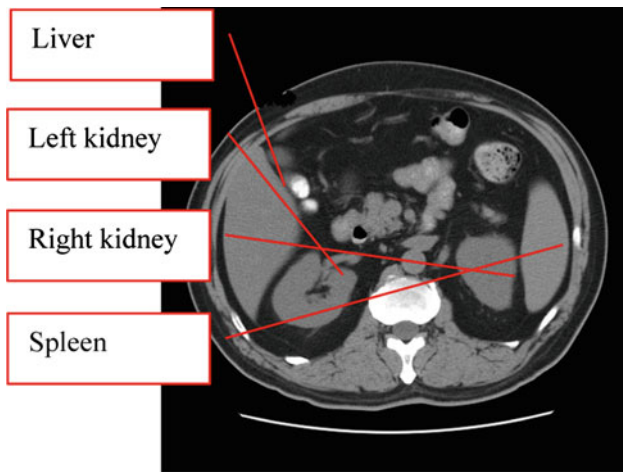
Original CT abdomen image X
